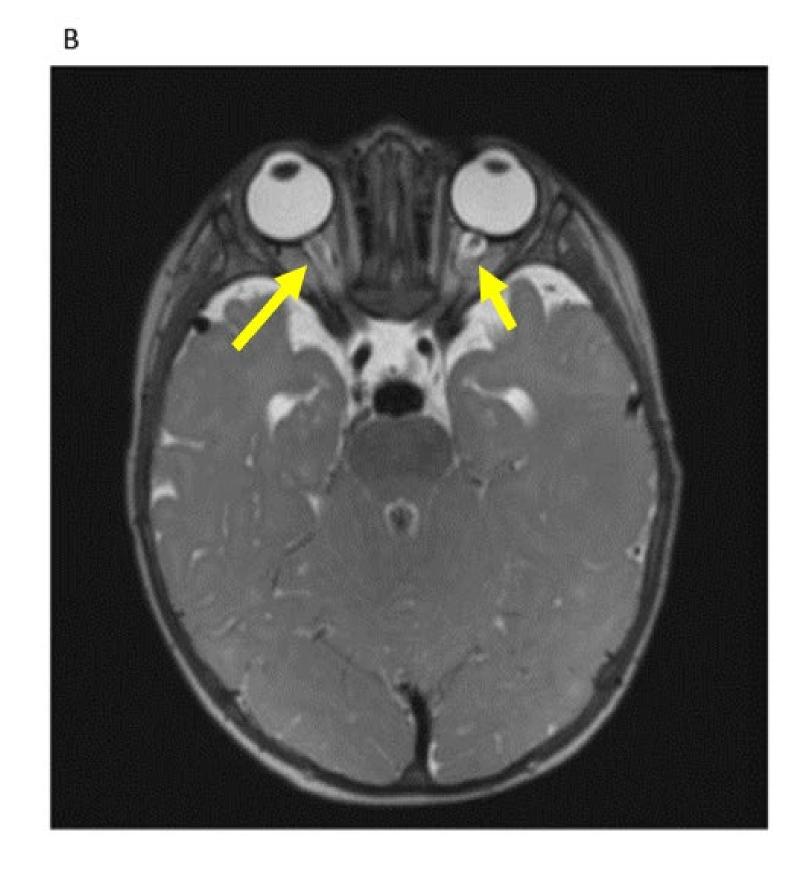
MRI brain and orbits with and without gadolinium contrast at 9 months of age. A. Axial cut, TI sequence showing enlargement of the lateral ventricles. B. Axial cut, T2 sequence showing prominent fluid along the optic nerve sheath bilaterally (yellow arrows). No post enhancement noted (image not shown).
